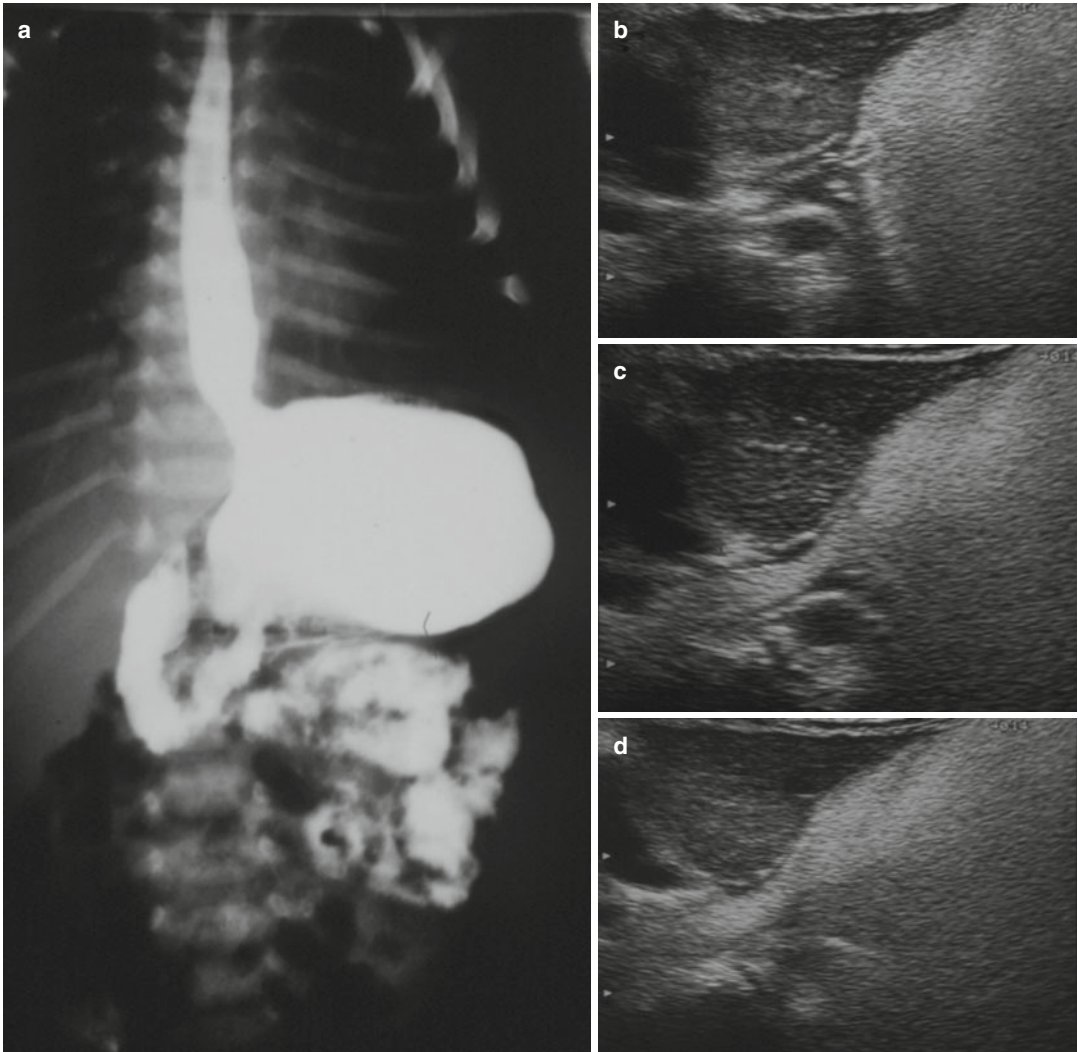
Infant with gastroesophageal reflux. (a) UGI radiographic examination shows clearly the reflux of contrast medium in distal esophagus. (b–d) Several phases of ultrasound examination of gastroesophageal junction: we
